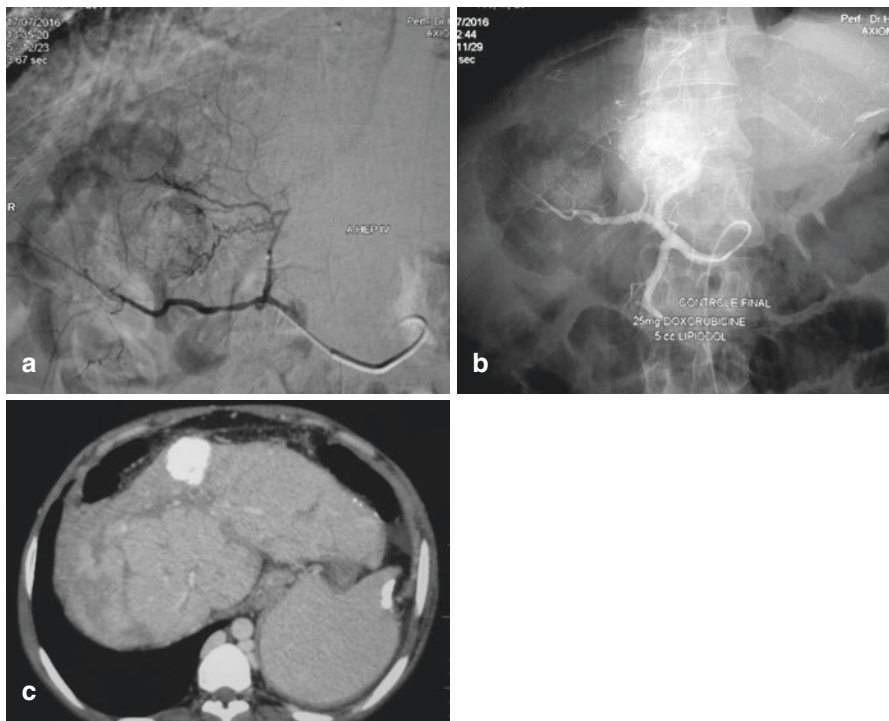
Transarterial chemoembolization in a 28-year-old patient with BCS associated with antiphospholipid syndrome. The three main veins were obstructed. A 28 mm HCC was diagnosed in 2016, located on segment IV with a high AFP level: (a) Angiography showing a vascular blush after injection in segment 4 artery; (b) Lipiodol fixation by the lesion at the end of the procedure; (c) CT scan one month after the procedure showing a good result. Lipiodol was equably distributed throughout the nodule (with courtesy of Pr SA. Faraoun and Dr A. Habouchi)
